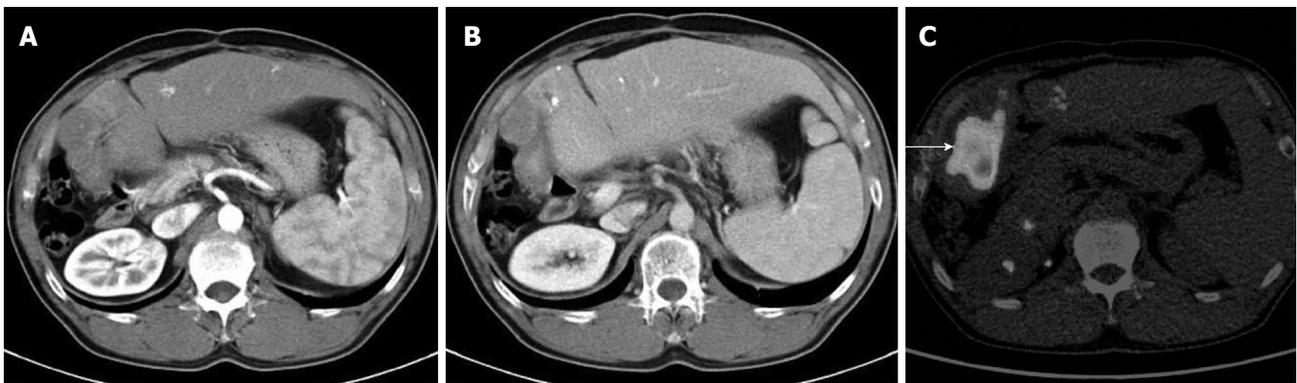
A case of recurrent hepatocellular carcinoma after right lobectomy. A, B: Arterial and portal phase of dynamic computed tomography (CT). Although tumor shadow was noted at the cut surface of the liver, it is difficult to determine recurrence due to poor enhancement; C: The tumor was diagnosed as recurrence of hepatocellular carcinoma because of strong fluorodeoxyglucose deposit (arrows).
